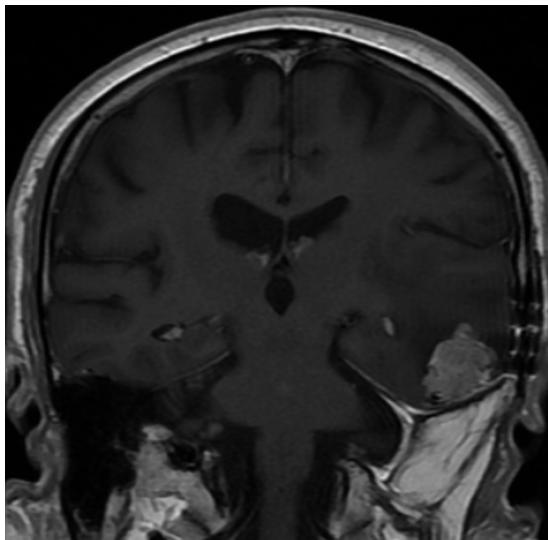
MRI showing the late recurrence in temporal lobe 12 years after surgery of the second case.
